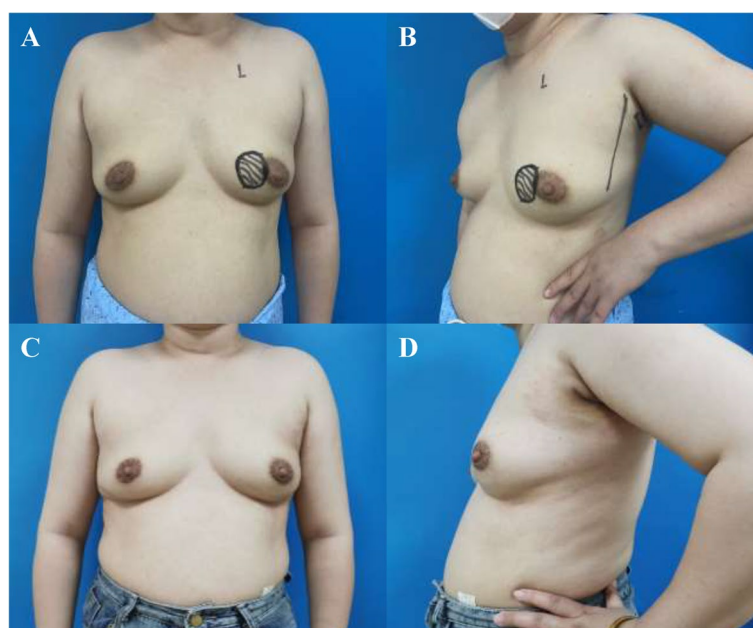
Comparison of preoperative and postoperative outcomes for a patient. A-B. Preoperative photos. Tumor location and extent were marked preoperatively under ultrasound guidance. The anterior axillary line was drawn, and the incision for the endoscopic surgery was planned. C-D. Follow-up photo of the patient at three months after surgery. The surgical incision was hidden, with good cosmetic results
